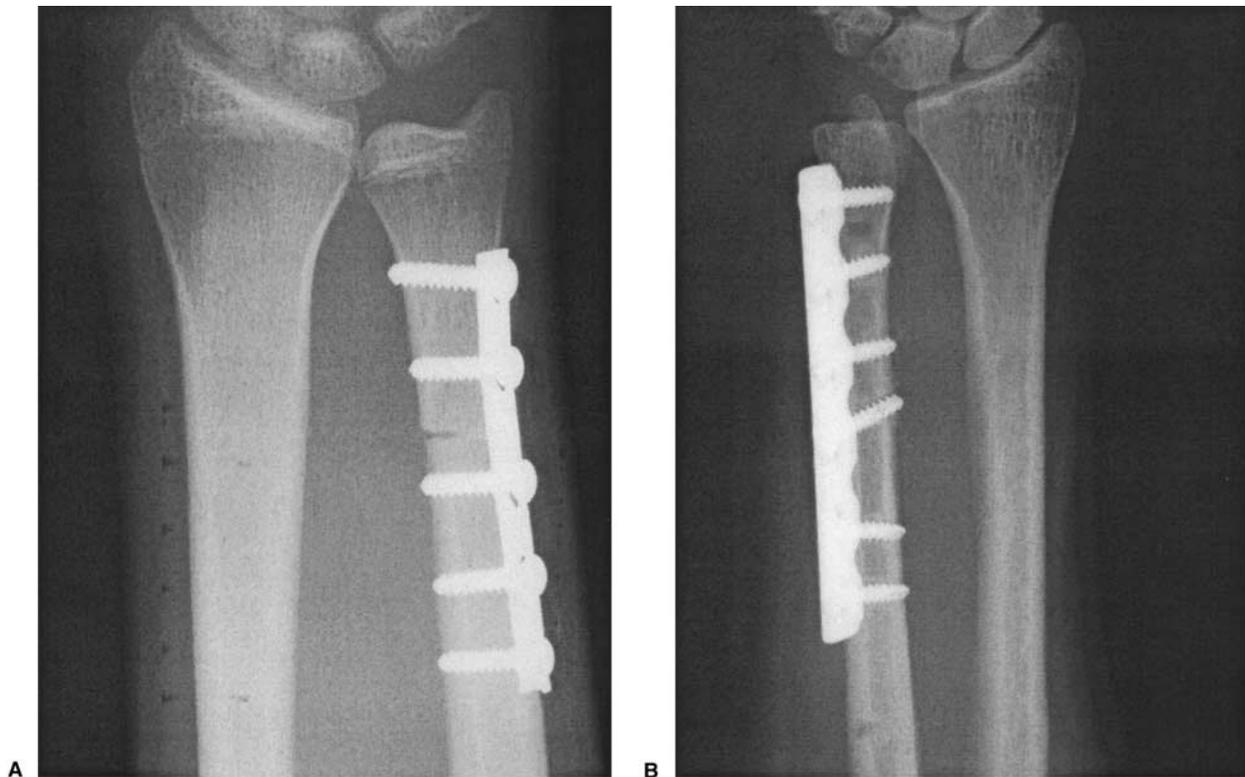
(A) Delayed union 5 months after a transverse osteotomy fixed with a third tubular plate and without an interfragmentary screw. (B) Comparison radiograph 6 weeks after oblique osteotomy fixed with interfragmentary screw and plate compression. A removable protective forearm splint was applied at 2 weeks after surgery and the patient was allowed wrist range of motion exercises. Note the unicortical hole proximal to the plate where the compression device was fixed temporarily.
